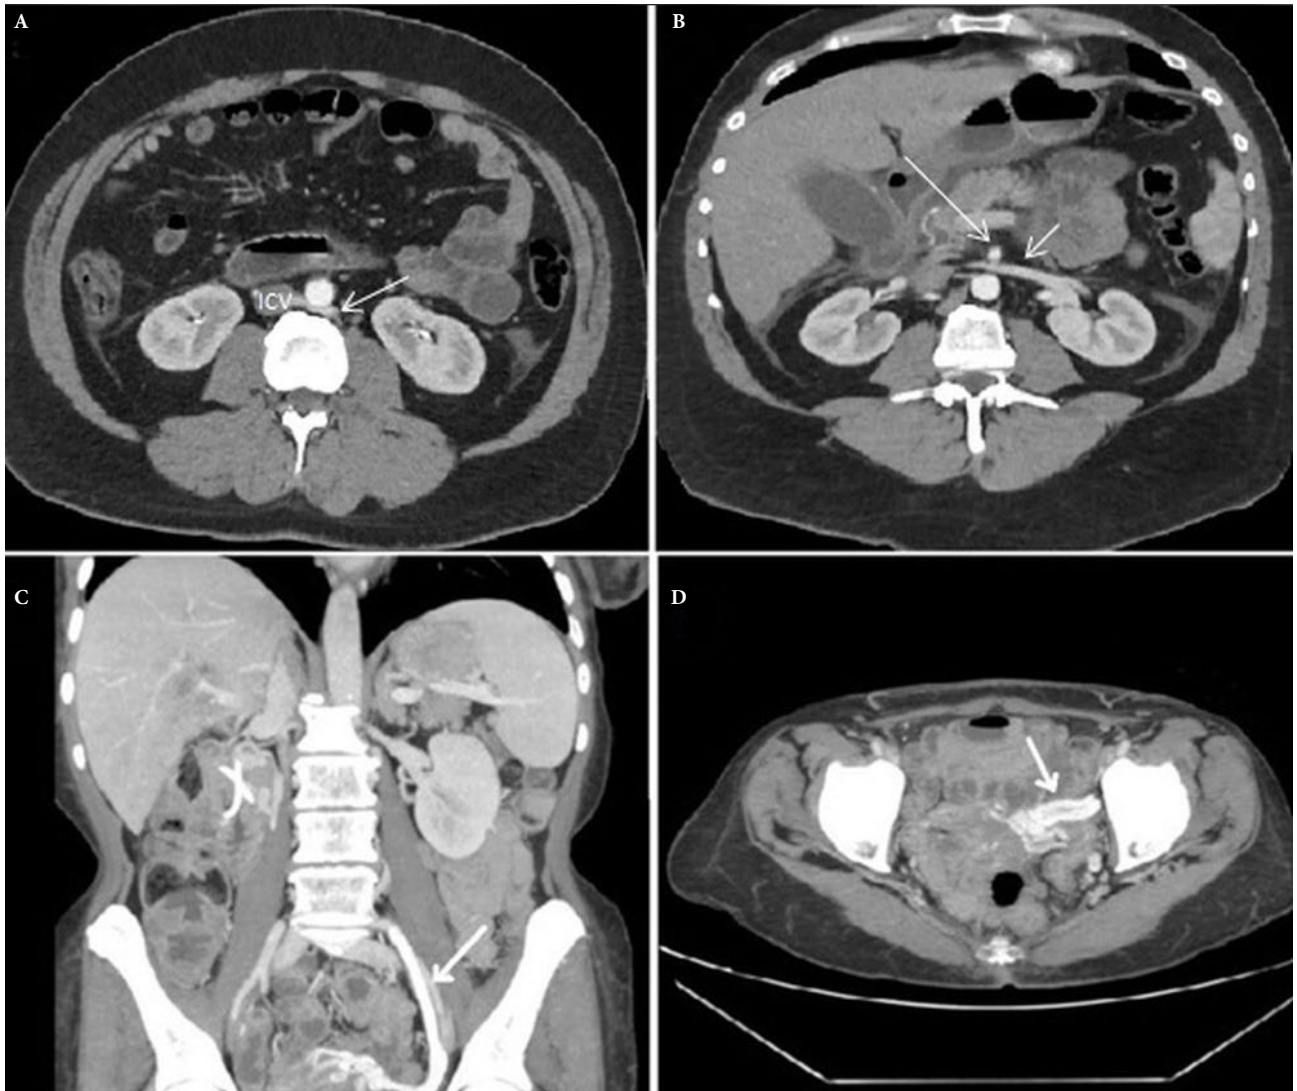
CT of double NCS. A. In this image, the retroaortic renal vein (arrow) appears compressed between the aorta and spine. ICV: Inferior cava vein. B. This image shows the anteroaortic renal vein (short arrow) which appears compressed in the space between the aorta and superior mesenteric artery (long arrow). C. This coronal view shows gonadal vein dilatation (arrow). d. This axial view shows varicosities of the gonadal plexus (arrows)
